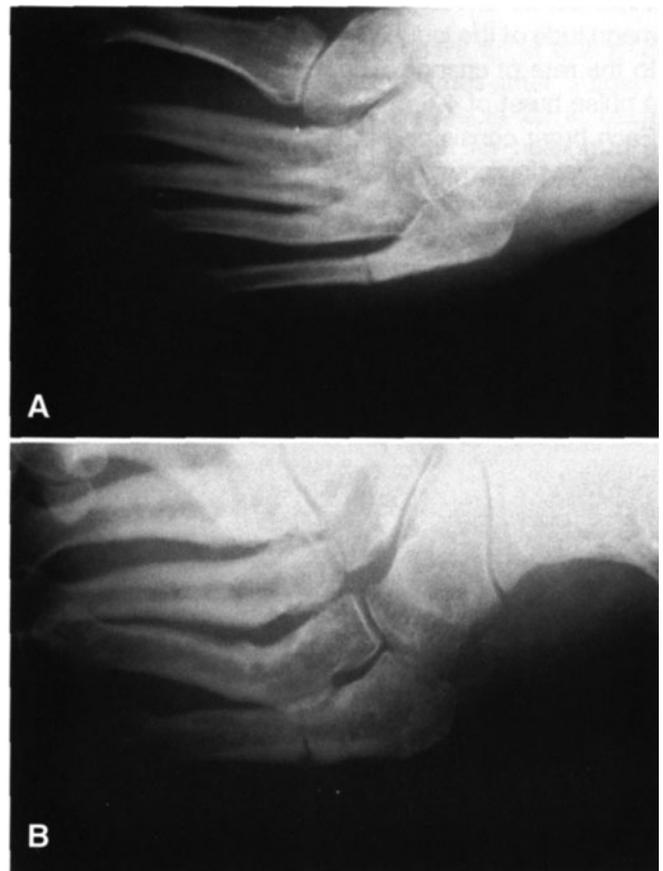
A, Anteroposterior radiograph of a Jones fracture with a delayed union. B, Oblique radiographs of a Jones fracture with a delayed union.
